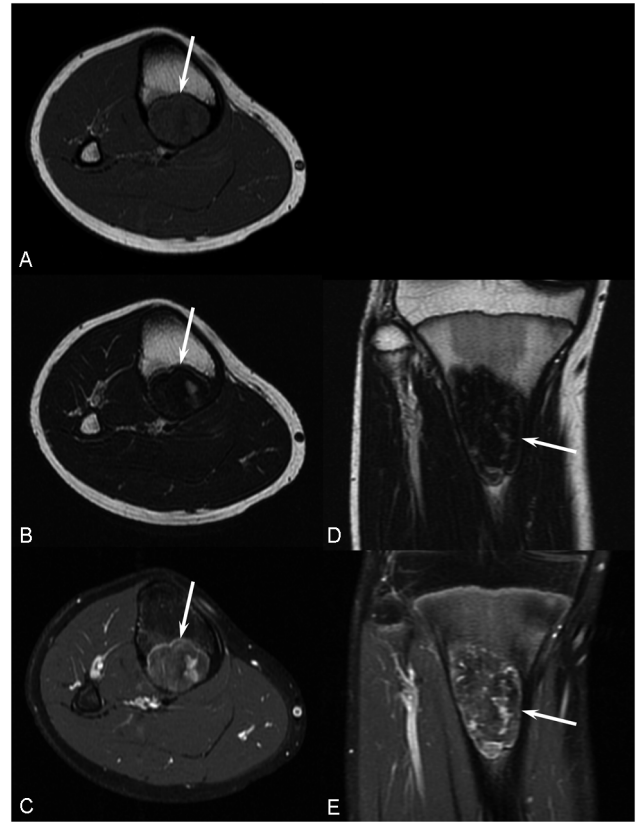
A 12-year-old man with nonossifying fibroma of the right tibia. Magnetic resonance imagings show a well-demarcated, eccentric, homogeneous lesion appearing isointense (arrow) on T1-weighted image (A), predominantly hypointense (arrows) on T2-weighted images (B/D) with hypointense rim, enhancing mildly (arrows) on fat-suppressed contrast-enhanced T1-weighted images (C/E).
